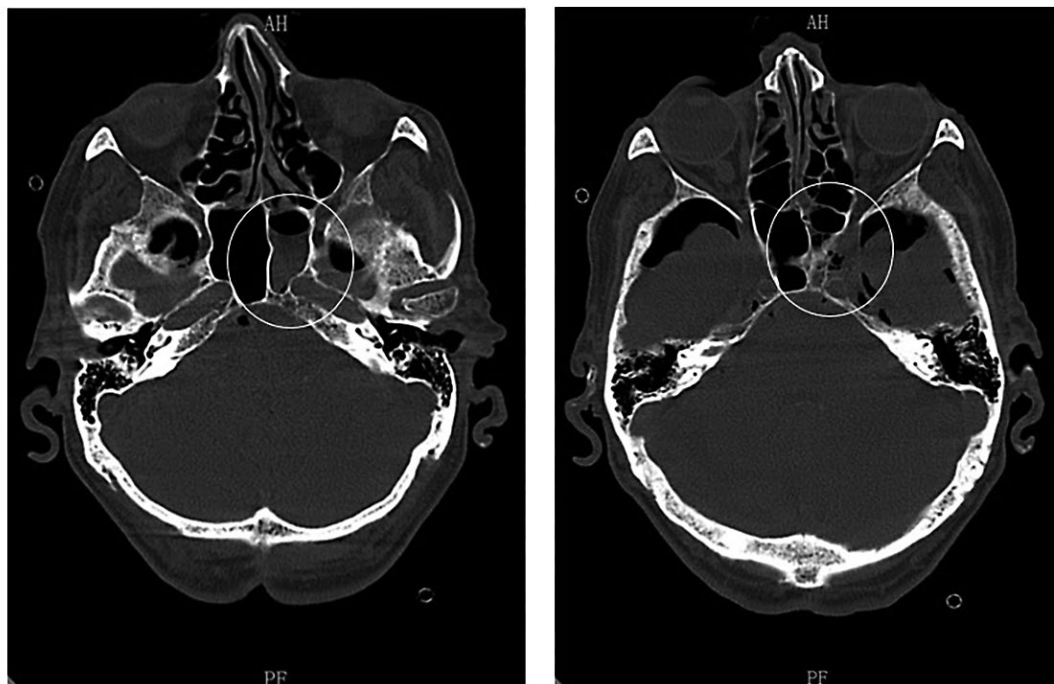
Head CT, bone window. A fracture in the left sphenoidal sinus was suspected by the detection of an air-fluid level, related to left sphenoidal hemossinus (white circles). No other fractures were found.
